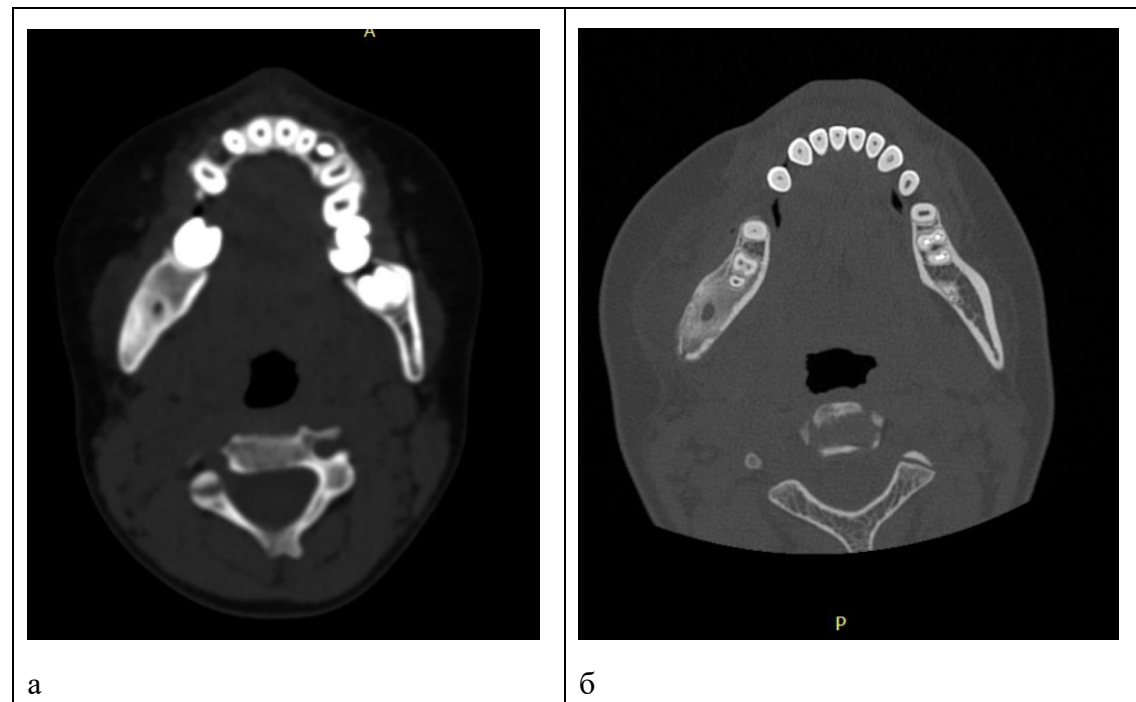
Multislice computed tomography data, axial sections, girls B., 7 years old (a) and girls K., 16 years old (b), with damage to the body of the mandible on the right and an increase in the width of the mandibular canal on this side.
